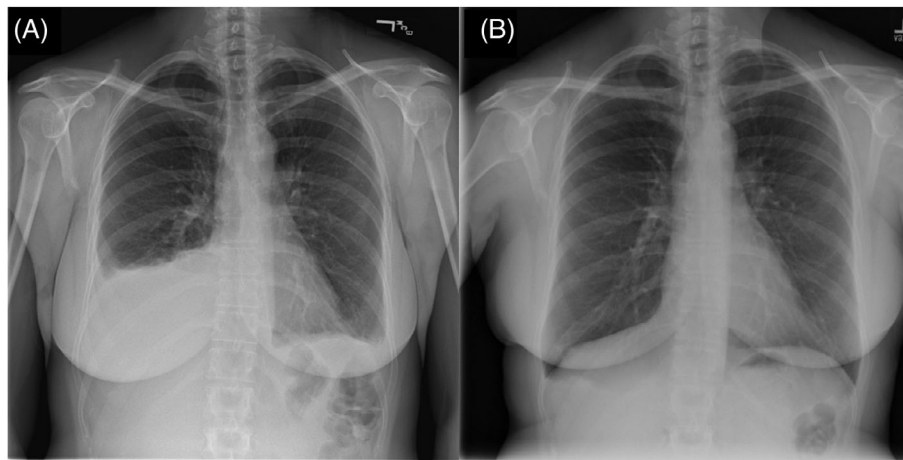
(A) Chest X-ray showing a right-sided pleural effusion on initial admission and (B) Chest X-ray showing no evidence of recurrent pleural effusions at 1-month follow-up after removal of ovarian hemangioma
